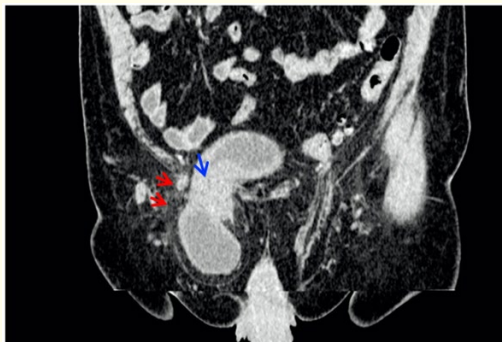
Coronal view of an abdomino-pelvic CT scan showing a right inguinal bladder hernia (red arrow), with associated infiltration of perivesical fat.
